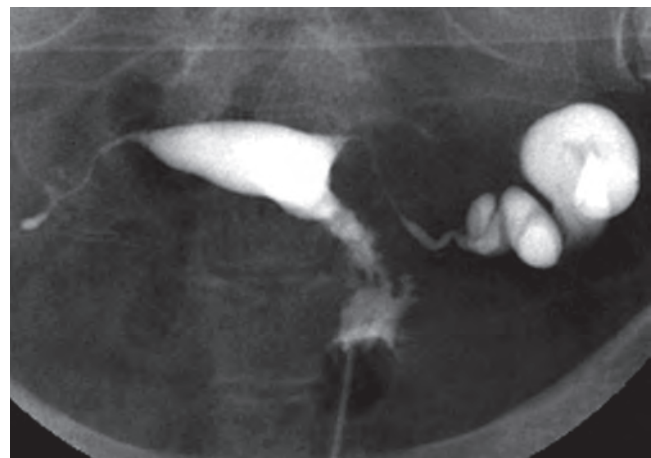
Hysterosalpingogram (HSG) showing the presence of a large hydrosalpinx in the left tube. (From Simpson WL Jr, Beitia LG, Mester J. Hysterosalpingography: a reemerging study. *Radiographics*. 2006;26:419–431.)
